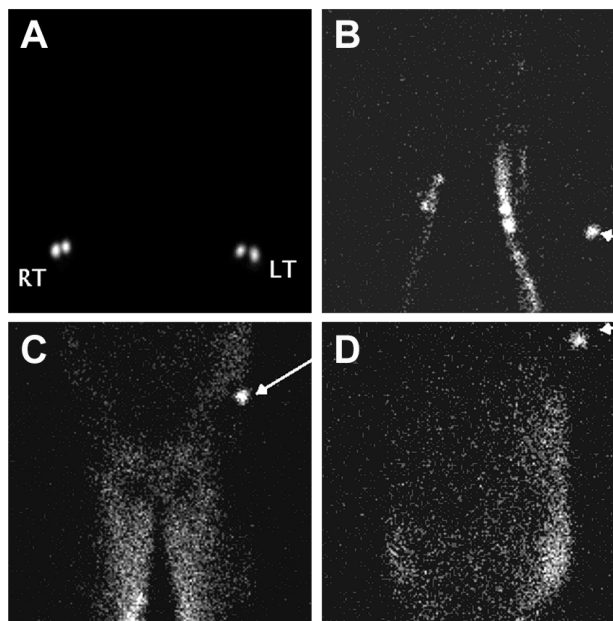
Lymphoscintigraphy findings. (A) Initial injection of radiotracer in both feet. (B) At 7 minutes, radiotracer is observed in normal lymphatic channels in the lower legs and in the popliteal lymph nodes. Normal lymphatics are not seen superior to the distal thighs (marker at the knee, arrow). (C,D) At 90 minutes, radiotracer is seen diffusely within the soft tissues of the thighs (C, marker at the iliac crests, arrow) and along the abdominal and thoracic walls (D, marker at the shoulder, arrow).
